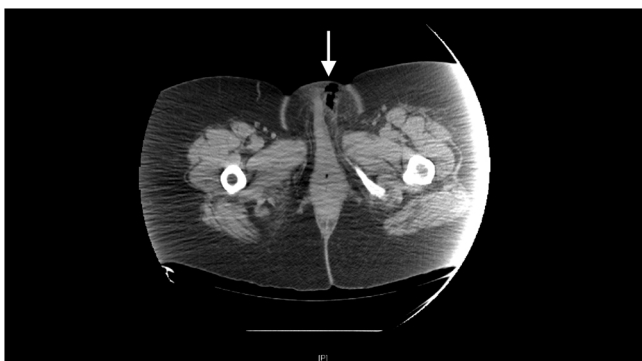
CT scan showing cutaneous ulceration overlying the left labia with air in the subcutaneous fat.
